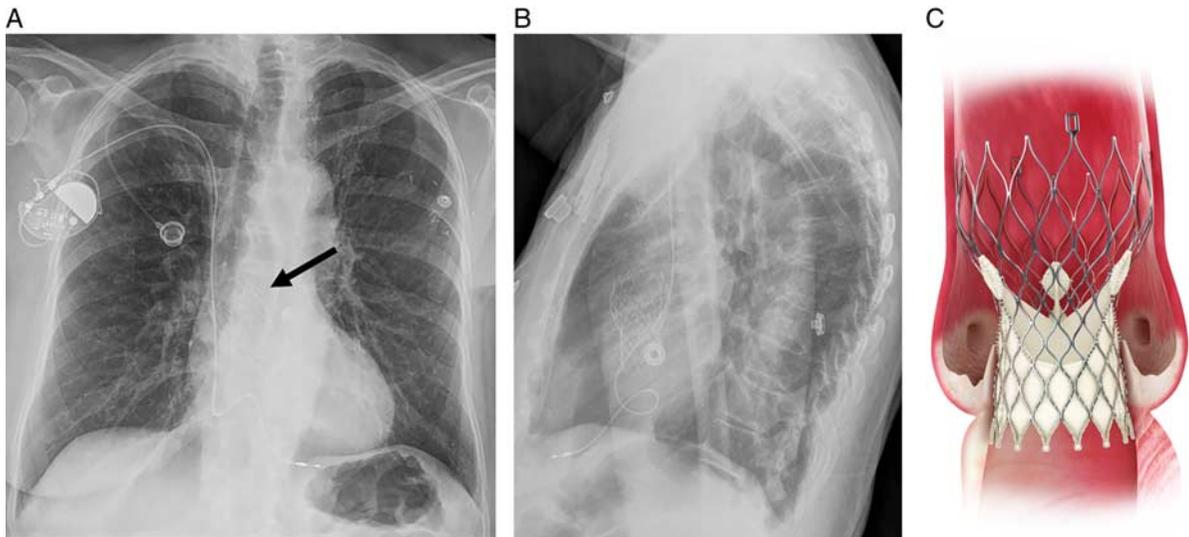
CoreValve after transcatheter aortic valve replacement (TAVR): frontal (A) and lateral (B) radiograph in patient after CoreValve TAVR. The valve is goblet shaped and anchors in the proximal tubular ascending aorta, above the sinus of Valsalva (black arrow). CoreValve (used with permission) (C). [full color online](#)
